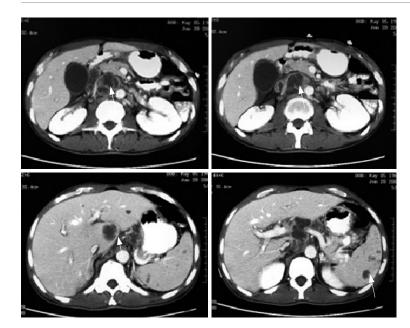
Abdominal CT with contrast showed cystic mass in the region of the body of pancreas and cystic lesions in the spleen and liver.
